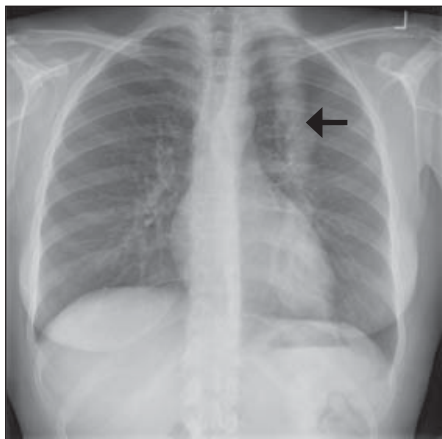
Chest X-ray showing odd opacity (arrow) in left hemithorax.
